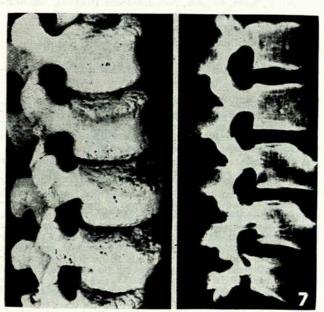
Lateral photograph and radiograph of remains of a girl aged 16 from the excavation of a Bronze Age barrow of about 1600 B.C. (Calvin Wells, Journal of Bone and Joint Surgery, August 1961 43B, 575. By kind permission.)
